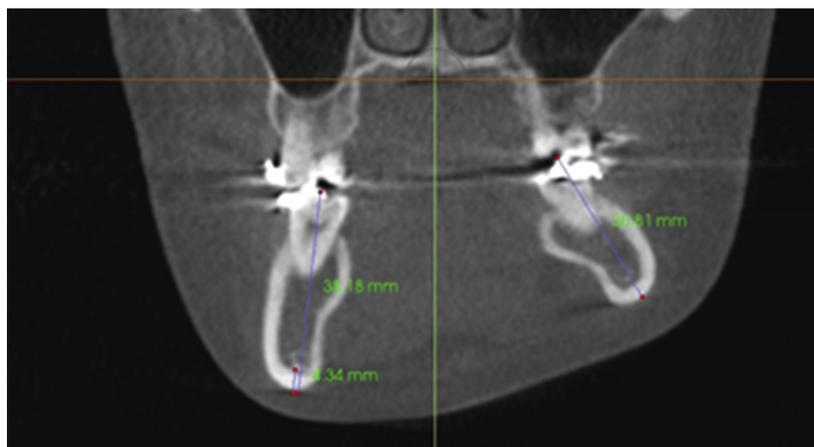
On CBCT, the vertical distance from the inferior alveolar nerve to the lower border of the mandible at the right first molar level is 4.5 mm. The distance from the right first molar to the lower border of the mandible is around 7 mm longer than the same position on the left side.
